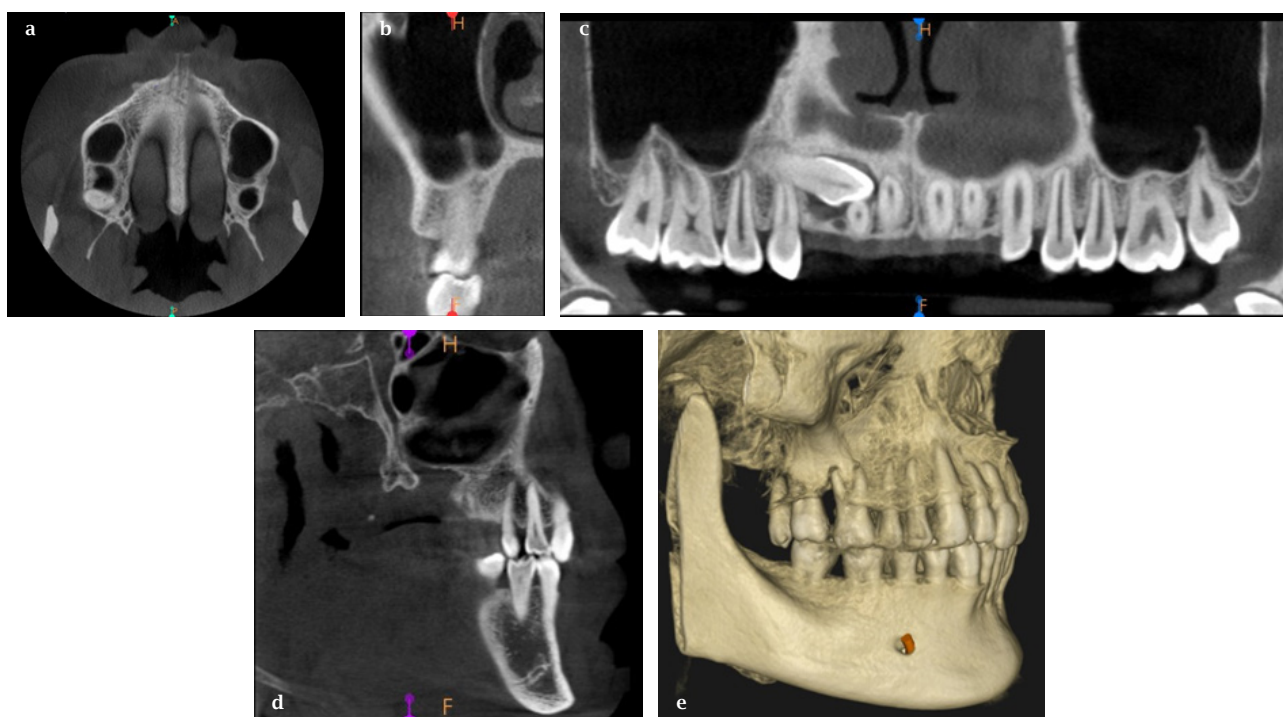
Reconstructed axial (a), cross-sectional (b), panoramic (c), sagittal (d) and 3 dimensional (e) CBCT images used for detection and measurement of maxillary sinus septa.
